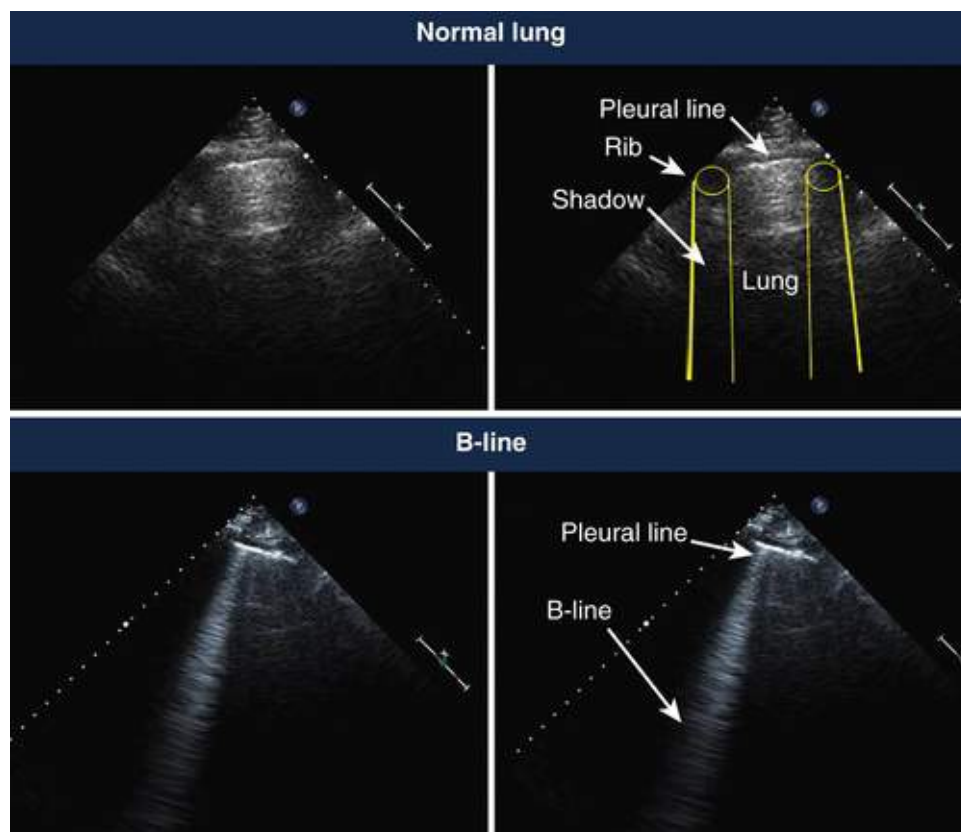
B-lines on lung ultrasound. For studies, typically the number of B-lines are summed from two to eight segments of the chest using a 1.5- to 7.5-mHz transducer. Top panels, Normal lung. Bottom panels, Example of B-line. Annotated images are on the right. (Courtesy Dr. Elke Platz, Brigham and Women's Hospital.)
